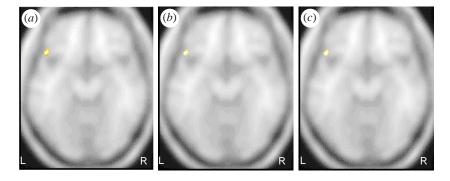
Statistical parametric maps (SPMs) superimposed onto normalized MRI-scans. The SPMs show significant activation of the left inferior frontal cortex (Brodmann area 47) for the following conditions: (a) faces expressing disgust compared with faces showing neutral expressions, (b) faces expressing fear compared with faces showing neutral expressions, and (c) faces expressing anger compared with faces showing neutral expressions. Talairach & Tournoux coordinates, \mathcal{Z} -scores and p-values are given in table 1.
